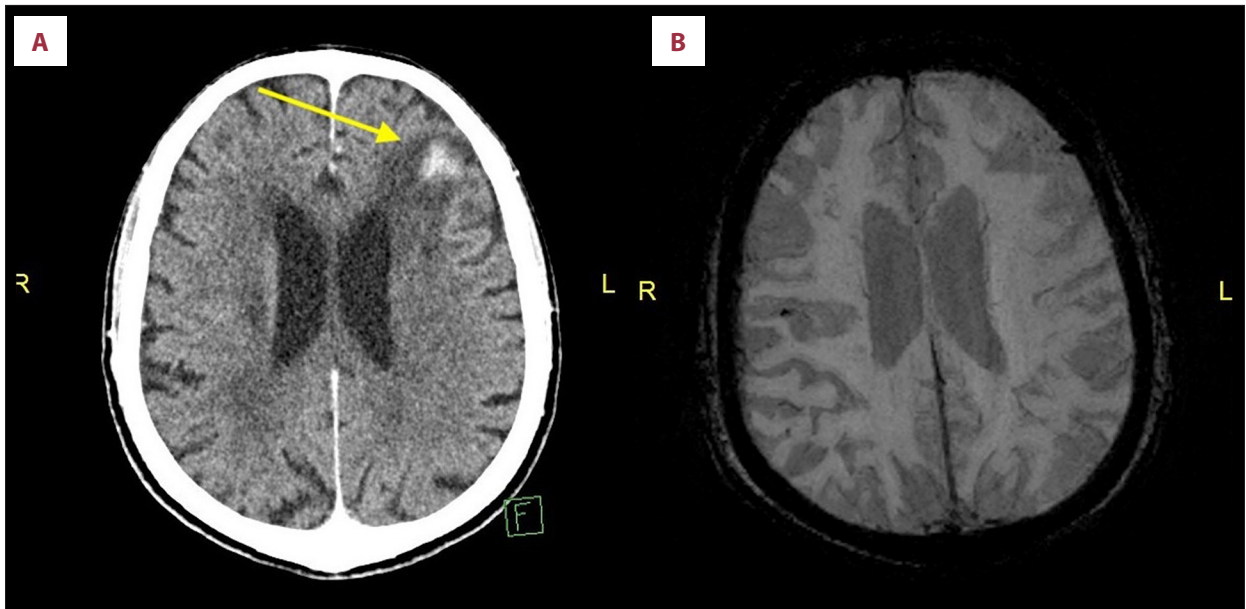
Axial view of CT head (A) showing hyperdense lesion in the left frontal lobe (yellow arrow) and SWI-MRI (B) of the corresponding section not showing any signal drop-out in areas corresponding to the hyperdensity.
